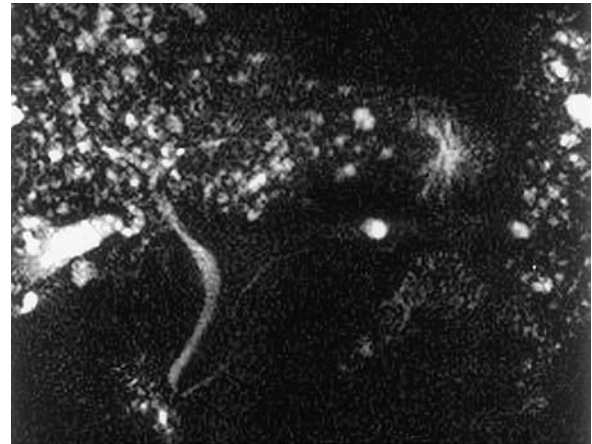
Biliary hamartomas in a 32-year-old woman. (a) Fast spin-echo T2-weighted MR image shows multiple small (<1.5-cm-diameter), hyperintense nodules consistent with biliary hamartomas. (b) Coronal projection MR cholangiogram shows that all of the lesions are smaller than 1.5 cm in diameter and do not communicate with the biliary tree. (c) Arterial-phase gadolinium-enhanced T1-weighted MR image shows that some of the lesions have rimlike peripheral enhancement (arrows).
